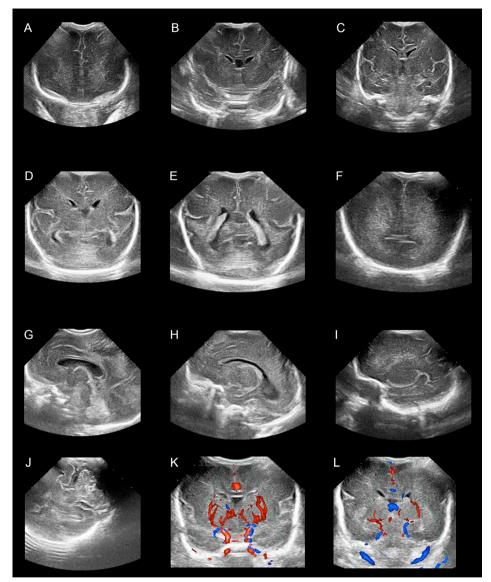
Ultrasound images were obtained in six coronal (A-F) and five sagittal/parasagittal planes (G-I) through the anterior fontanel. Additional images were acquired through the mastoid fontanel (J) to visualize the cerebellum and color Doppler images (K-L) were acquired to assess arterial and (sino-) venous systems.
